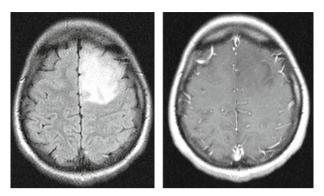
Left frontal anaplastic astrocytoma which has a strong signal intensity in the FLAIR (*left*) but has only very limited uptake of contrast in the T1 (*right*)
